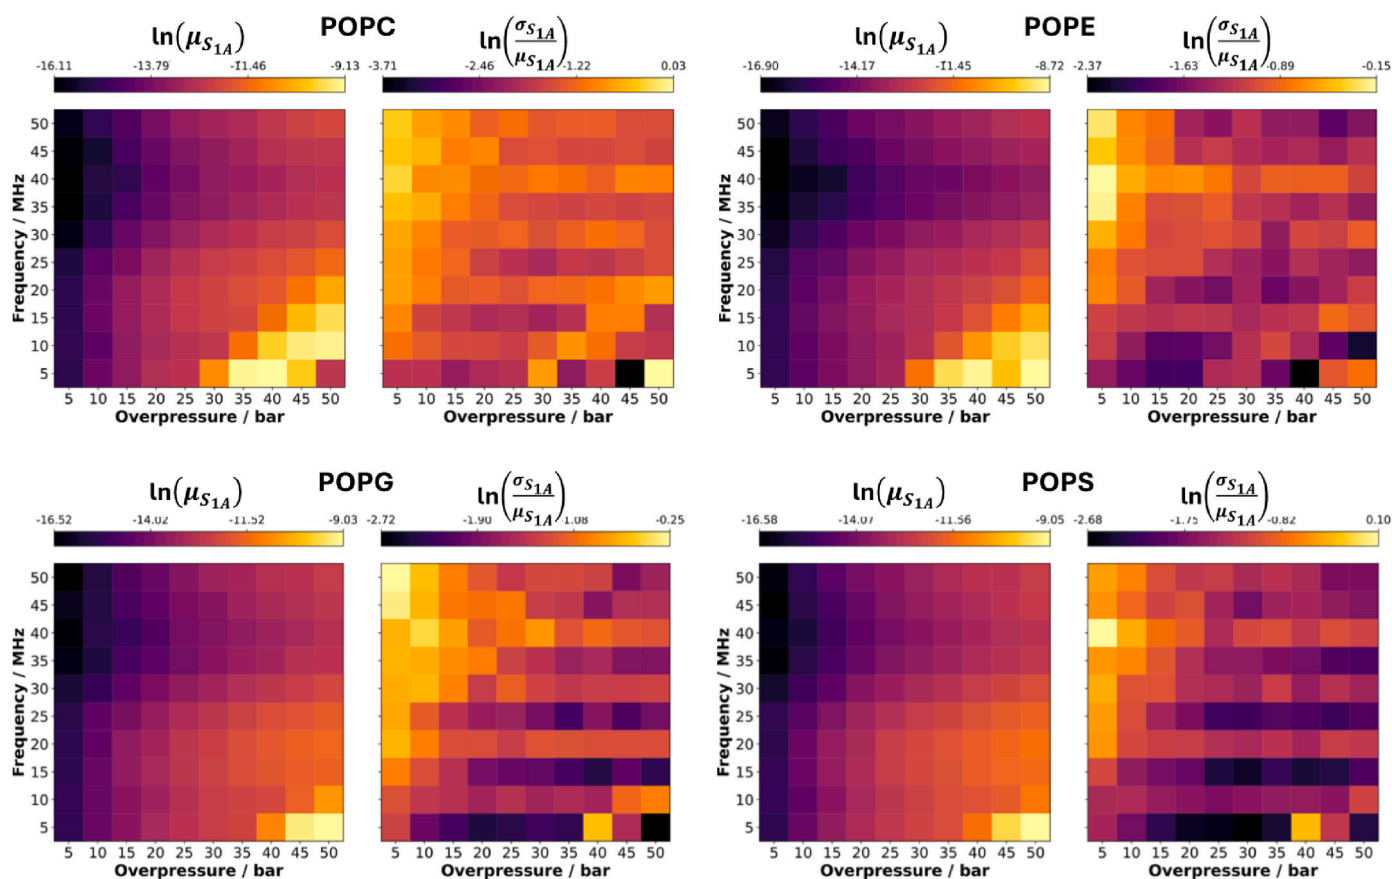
Order parameter (OP) for the response of the first bead of SN1 of the studied systems under varying ultrasound conditions. Two heatmaps are plotted for each lipid bilayer: Logarithm of mean OP, $\ln(\mu_{S1A})$, showing average membrane expansion or compression (left); and Logarithm of relative OP fluctuations, $\ln(\sigma_{S1A}/\mu_{S1A})$, indicating the magnitude of OP variations relative to its average value (right). Color scale: Blue indicates lower values, red higher values. This logarithmic representation enhances visibility of subtle variations across different ultrasound parameter regimes. (For interpretation of the references to colour in this figure legend, the reader is referred to the Web version of this article.)
